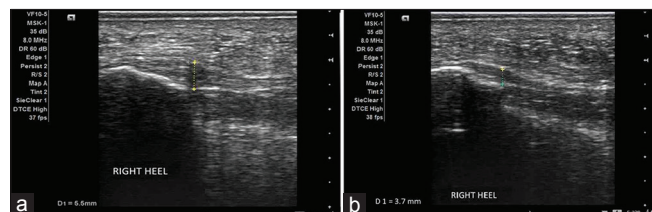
(a) Preplatelet-rich plasma injection ultrasound-guided right heel plantar fascia thickness (5.5 mm). (b) Postplatelet-rich plasma injection ultrasound-guided right heel plantar fascia thickness (3.7 mm)
